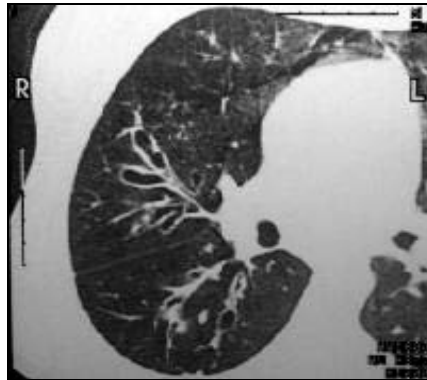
CT scan shows areas of both cystic bronchiectasis and varicose bronchiectasis (*Tsang et al., 2005*).
